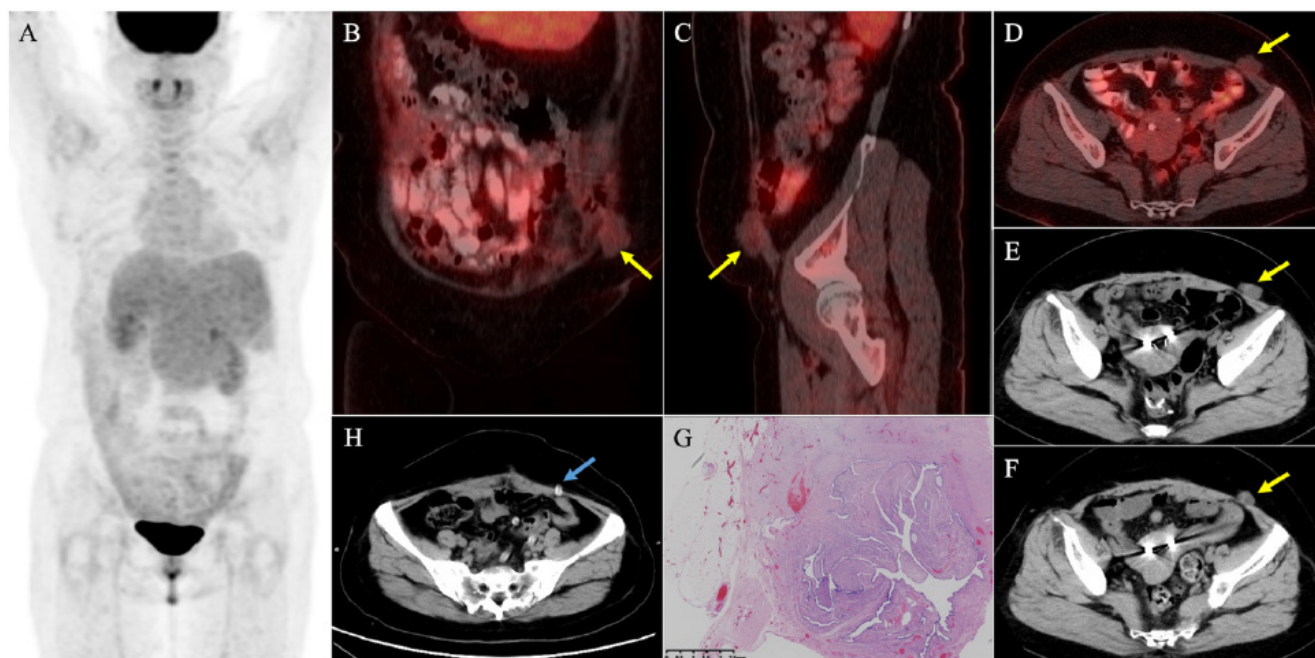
A 55-year-old woman with sigmoid colon cancer underwent laparoscopic sigmoid colectomy three years ago. Eight months after colectomy, she underwent right hepatectomy and chemotherapy because of newly diagnosed liver metastasis. Eight months after chemotherapy, the patient incidentally found a subcutaneous palpable hard mass in the left lower abdomen with slight intermittent abdominal discomfort. During follow-up, the mass gradually enlarged, while serum carcinoembryonic antigen levels remained within the normal range (2.6 to 3.3 ng/mL, normal reference range: 0-5.0 ng/mL). Twelve months after the discovery of the mass, an ^{18}F -fluorodeoxyglucose (FDG) positron emission tomography/computed tomography (PET/CT) scan was conducted for further diagnosis and staging [(A) maximum intensity projection, (B) coronal PET/CT, (C) sagittal PET/CT, (D) axial PET/CT], revealing an irregularly shaped subcutaneous mass in the left lower abdomen (B, C, and D, yellow arrow). The mass was closely related to the abdominal wall (without a remarkable defect) and showed mild uptake of ^{18}F -FDG (maximum standardized uptake value: 1.2). We then reviewed the serial CT scans (E and F, 6 and 12 months before the PET/CT scan), which demonstrated that the mass enlarged and became irregular. Therefore, the possibility of metastasis was raised. However, post-surgery and pathological confirmation (G, fallopian tube tissue could be seen in the fibrous and fatty tissue), this mass was finally diagnosed as a drain-site hernia (DSH) containing fallopian tube fimbria. We reviewed all previous CT scans of the patient and confirmed that the mass was indeed located above the former 5 mm drain site (H, blue arrow). In addition, the mass appeared six months post-colectomy and gradually enlarged, but it was missed by the radiologist. This misdiagnosis should serve as a reminder of the following three lessons. First, we should enhance and broaden our understanding of rare hernias. Trocar site hernia (TSH) is rare and is defined as an incisional hernia occurring at the trocar incision site after laparoscopic surgery (1). Among TSH, DSH is an even rarer type, occurring at the port site where the drainage tube is placed (2). Its prevalence ranges from 0.1% to 3.4% according to the literature. Trocar size is the dominant risk factor for DSH, which often occurs at the ≥ 10 mm port site and rarely occurs at the 5 mm port site (as observed in this patient) (3,4,5). Second, we need to broaden and improve our knowledge of the atypical contents of hernias. The most common contents of hernias are the small bowel and omentum. The uncommon hernia contents, such as the fallopian tube in this case, appendix, ovary, gall bladder, and bladder, are rare but cannot be ignored (2,6,7,8). It should be noted that any organ within the abdominal cavity might herniate. DSH-containing fallopian tubes are extremely rare, with only three cases reported (6,7,8). Finally, a thorough review of previous clinical image data and patient history is essential for accurate diagnosis. If we could comprehensively review all previous CT scans, this misdiagnosis might be avoided. In summary, although a DSH containing the fallopian tube fimbria is extremely rare, this misdiagnosed case suggests that it should be considered in the differential diagnosis of a subcutaneous mass in the lower abdomen.
